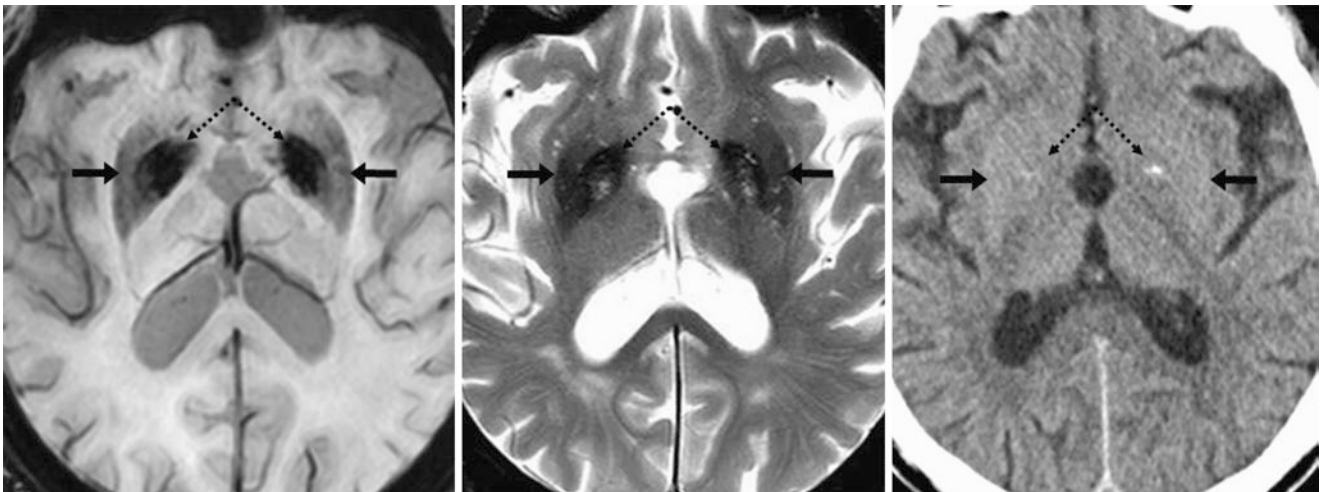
An 81 year old had a negative 3T MRI performed for altered mental status. An SWI (*left*) demonstrates iron deposition within the lentiform nuclei (i.e., GP [*dotted arrows*] and putamina [*arrows*]).
